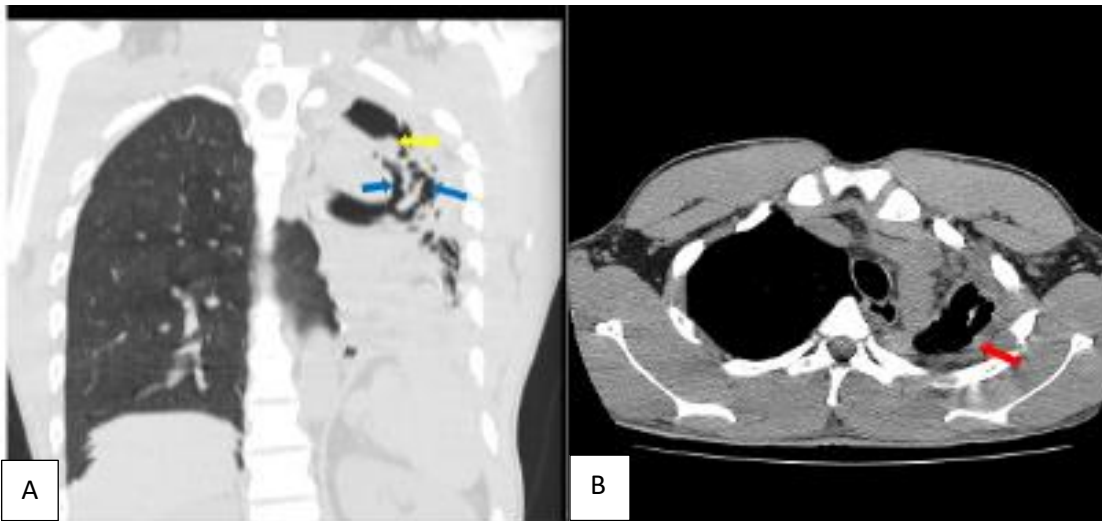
Axial non contrast CT scan, coronal reformatted lung, and axial mediastinal windows of the chest of the patient diagnosed with CPA at T1 A). Extensive left lung traction bronchiectasis (blue arrows) with ipsilateral lung volume loss, left apical lung cavity with intracavitary material (yellow arrow), B) left apical lung pericavitary pleural thickening (red arrow).
